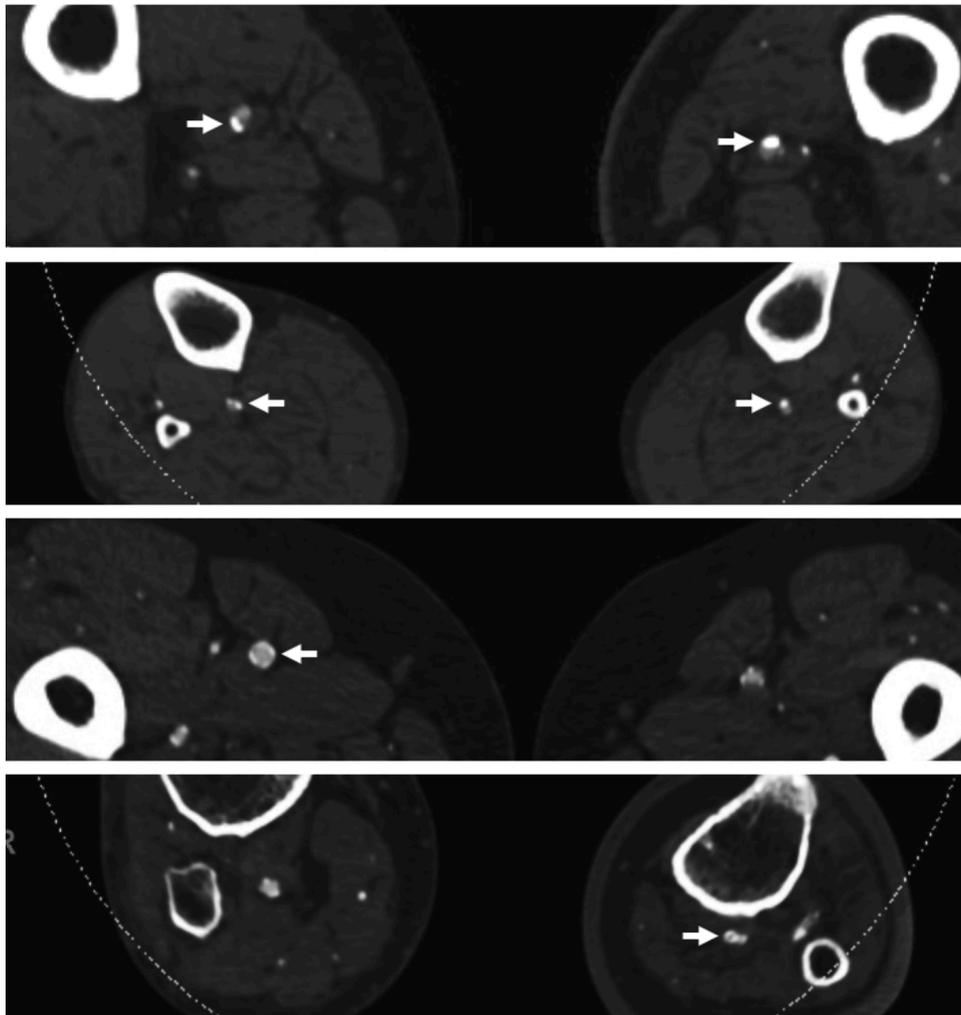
Axial CT angiography slides at the level of the femoral and crural arteries. Top two figures: examples of incomplete annular ($<270^\circ$) and thick calcifications (indicating dominant intimal calcifications). Bottom two figures: examples of complete annular ($>270^\circ$) calcifications and thin calcifications (indicating dominant medial calcifications).
